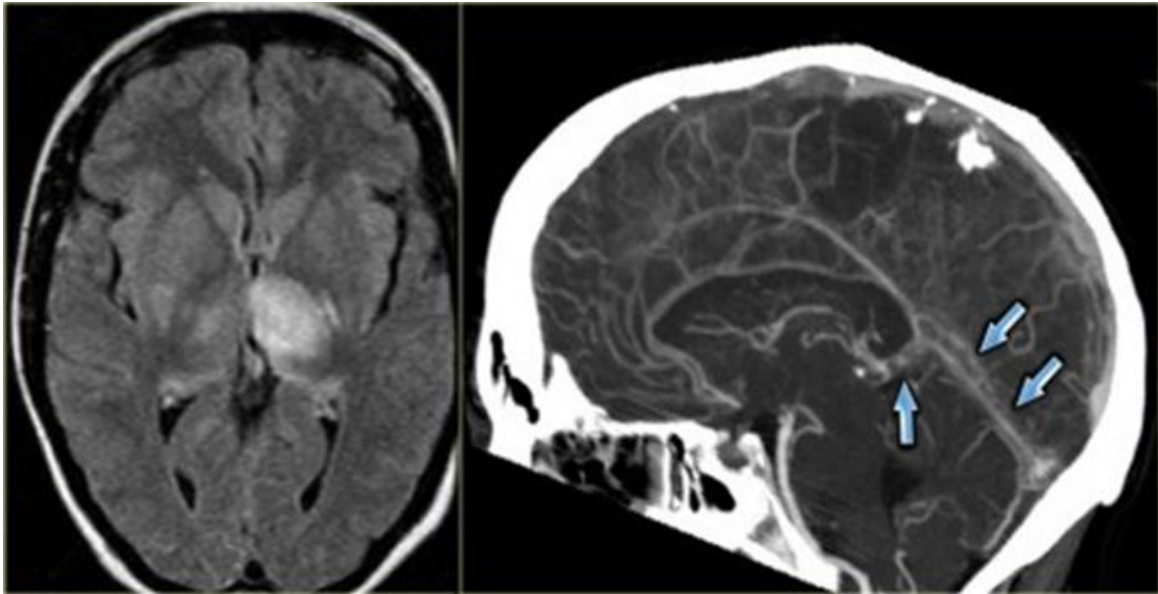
On the left a FLAIR image demonstrating high signal in the left thalamus. there is also high signal in the basal ganglia on the right. These bilateral findings should raise the suspicion of deep cerebral venous thrombosis A sagittal CT reconstruction demonstrates a filling defect in the straight sinus and the vein of Galen (arrows).
